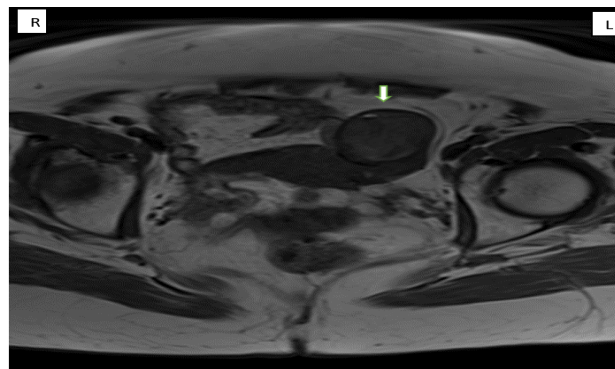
Non-contrast MRI Pelvis: Axial T1.
